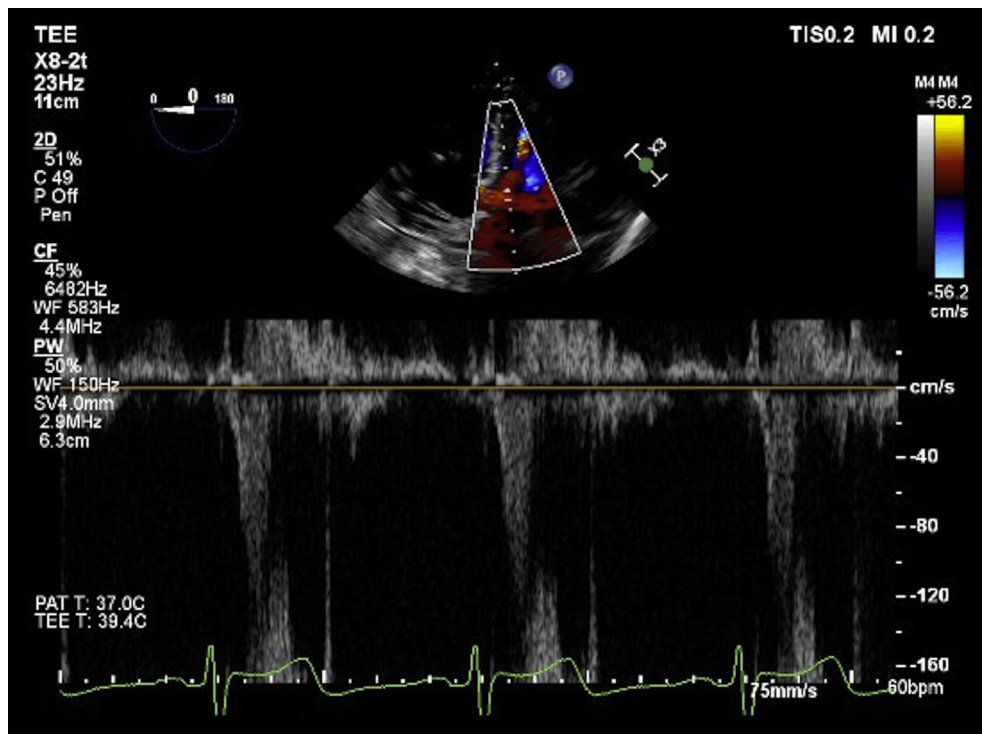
Pulsed-wave Doppler showing a peak LVOT velocity of approximately 1.3 m/sec but limited by aliasing.
